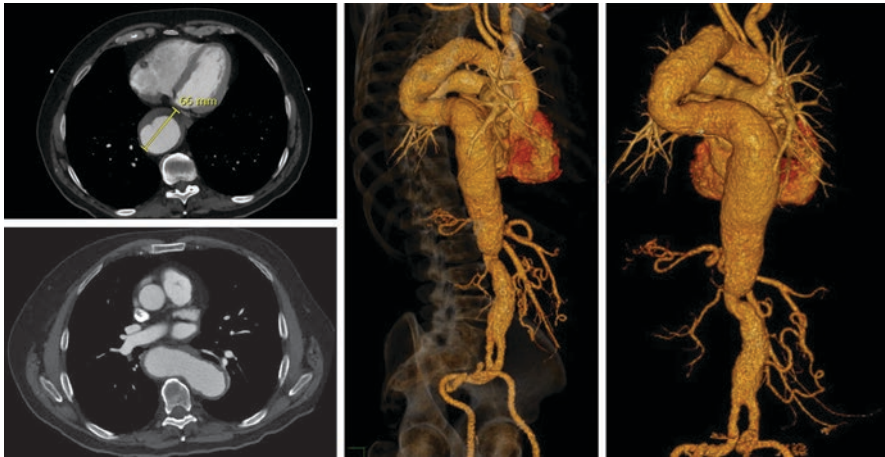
Axial contrast CT scans and 3D reconstructions demonstrating degenerating elongating descending thoracic aortic aneurysm which dilates from the proximal descending portion down to the diaphragm
